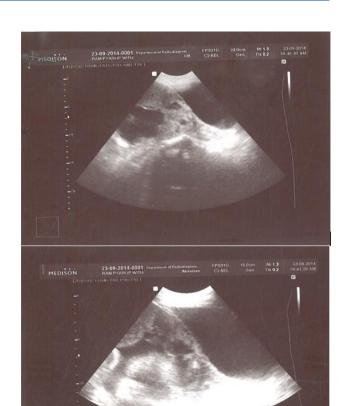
Ultrasonography showing morbidly adherent placenta.
